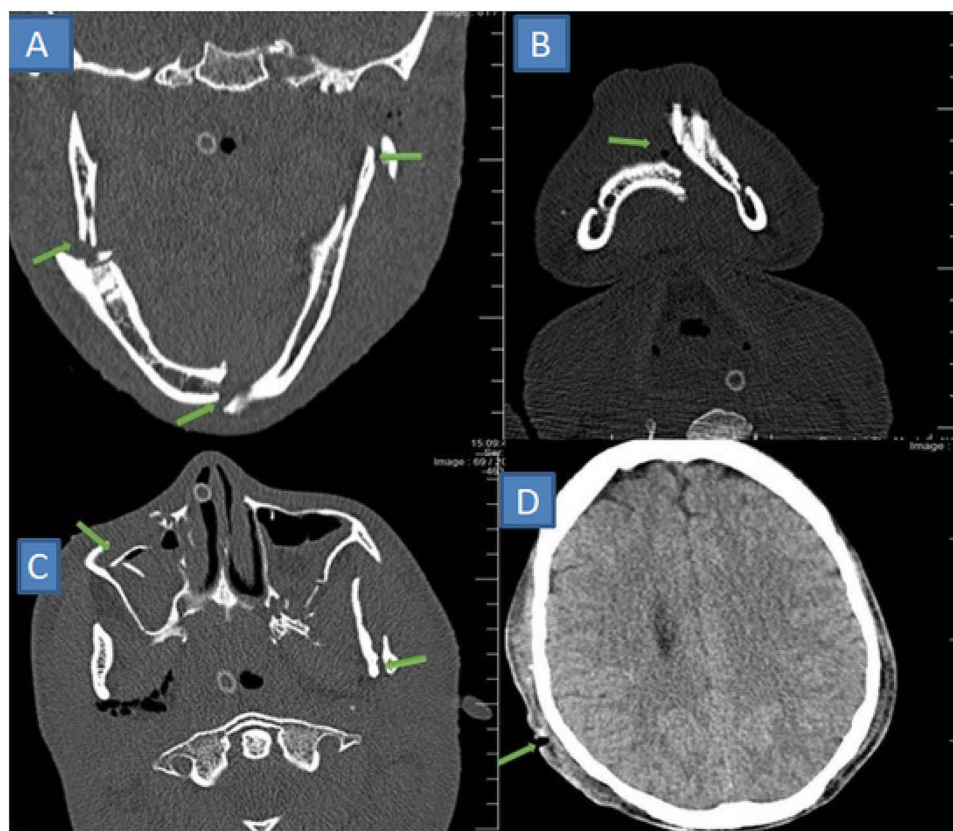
The head and maxillofacial CT examination revealed displaced fractures of the bilateral mandibular condyles, anterior mandibular body, and bilateral maxillary sinus walls, as seen in the coronal (A), axial (B), and sagittal (C) views, respectively. The brain window scalp (D) also demonstrated scalp lacerations (indicated by arrows).
